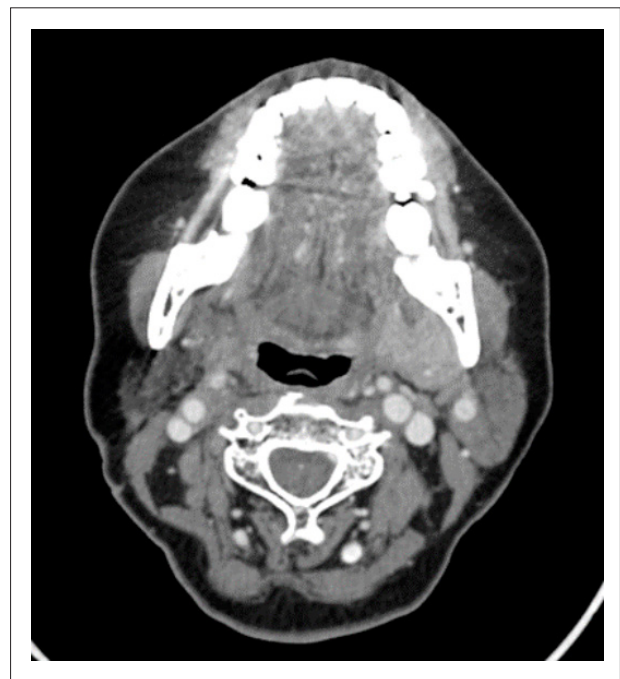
Computed Tomography after Radiotherapy 60 months.
